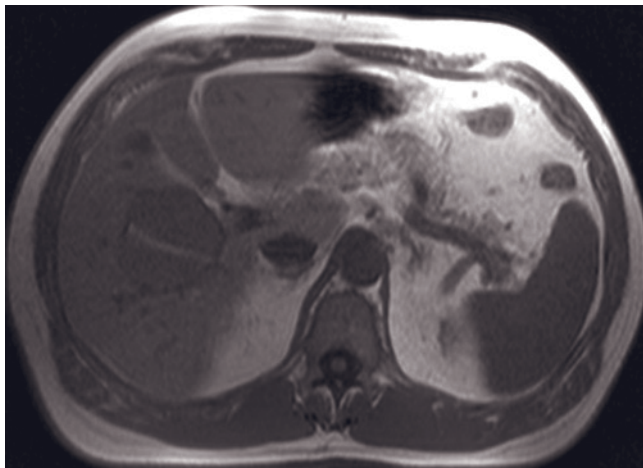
Biliary cystadenoma. T2-weighted fat-suppressed ETSE (*a*), SGE (*b*), and immediate postgadolinium SGE (*c*) images. A large cystic mass with a 5-cm solid nodular component (arrow, *b*) is present in the liver. The nodular component is moderately hyperintense on the T2-weighted image (*a*) and slightly hypointense on the T1-weighted image (*b*) and enhances in a diffuse heterogeneous fashion on the immediate postgadolinium image (*c*). Diffuse heterogeneous enhancement on immediate postgadolinium images is a feature of tumors of hepatic origin.
